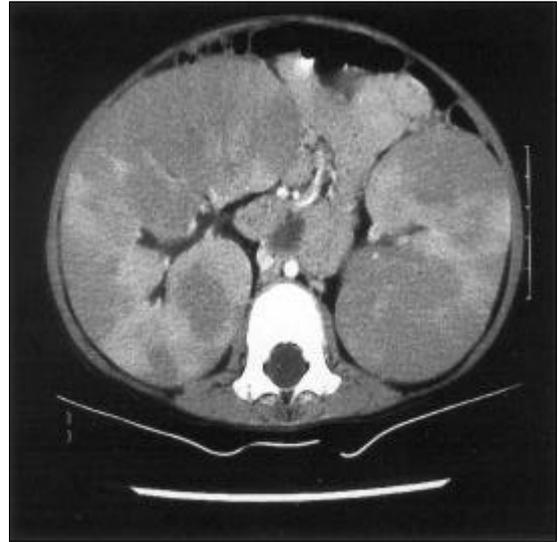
The abdomen CT reveals diffuse enlargement of both kidneys, but without architectural distortion. The renal pelvis is symmetrically enhanced without hydronephrosis.
